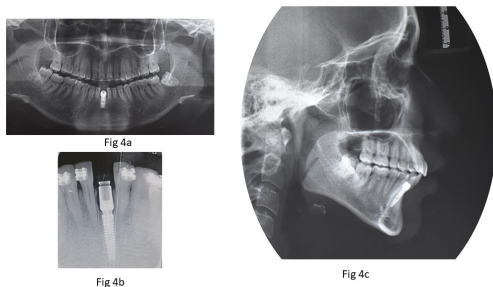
Post operative radiographs after implant placement
